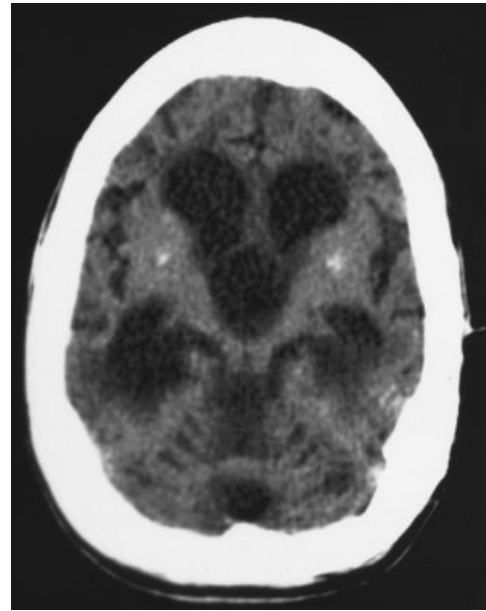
Head computed tomography (CT) without contrast obtained at 20 years old. This axial image reveals calcifications of the globus pallidus, and ventriculomegaly with prominence of the cerebral sulci and cerebellar fissures, associated with marked ventriculomegaly, consistent with severe global atrophy. The white matter volume appears reduced with periventricular white matter hypodensity. The calvarium appears diffusely thickened.
